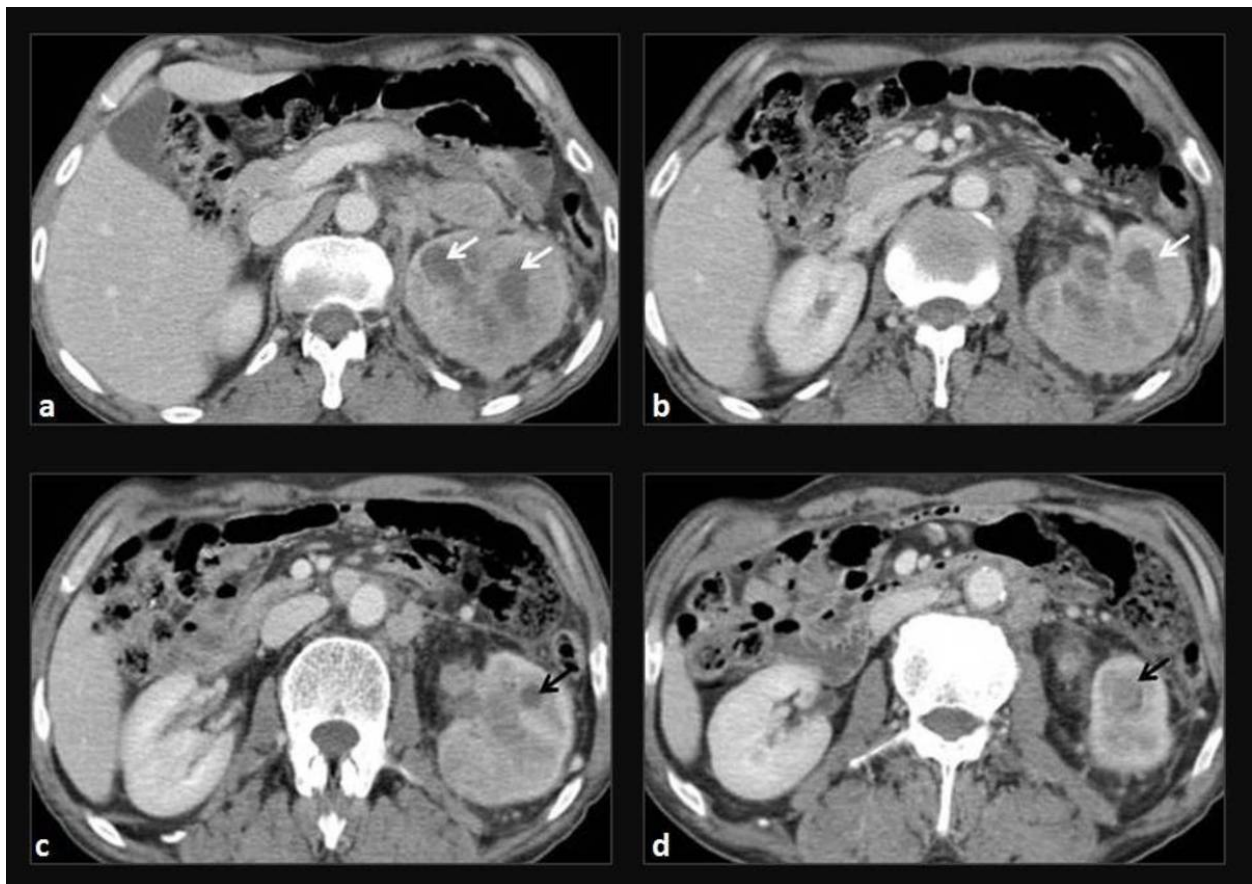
Multiple renal abscesses. Axial contrast-enhanced CT images show an enlarged and heterogeneous left kidney, with multiple hypodense collections representing abscesses (white arrows). There is also dilatation of several calyces in the lower pole, which are filled with dense material (pyonephrosis) (black arrows).
